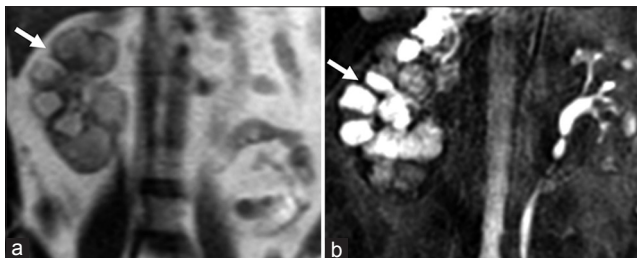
51-year-old woman with renal tuberculosis. (a) Coronal T2-weighted (T2W) and (b) heavily T2W (long TR) magnetic resonance (MR) images reveal grossly hydronephrotic right kidney (arrow) due to chronic upper ureteric tubercular stricture.
